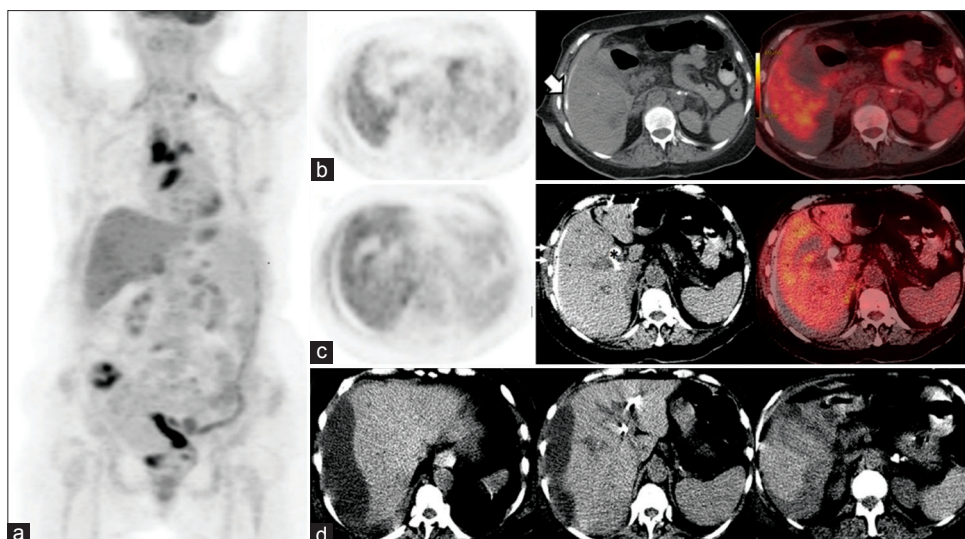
Besides hypermetabolic primary tumor in cecum, peritoneal carcinomatosis, metastatic lung nodules and bilateral adrenal metastasis. ([a] maximum intensity projection image), there was a prominent mismatch between positron emission tomography (PET) and computed tomography (CT) boundaries of the liver mimicking coregistration artifact ([b] PET, CT and fusion PET/CT images). On the PET/CT images, percutaneous transhepatic biliary drainage-related findings were also observed, such as the presence of contrast material within the main hepatic and dilated intrahepatic bile ducts (star in c), small air bubbles (thin arrows in c) and curvilinear hyperdensity surrounding the lateral border of the right lobe of the liver in the perihepatic space (thick arrow in b). Three weeks later, a follow-up abdominal CT showed a large subcapsular collection with mixed attenuation (with CT numbers of 4 and 31 Hounsfield units) (d)
